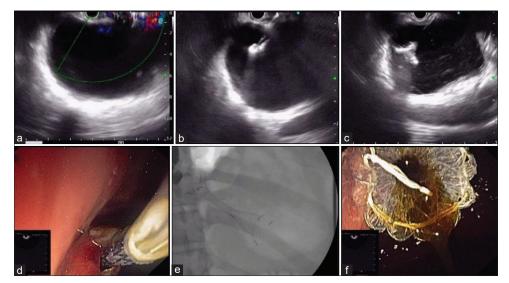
(a) EUS shows a pseudocyst and colour Doppler shows no intervening vessels. (b) Puncture of pseudocyst with 10-French cystotome. (c) Flanges of the stent seen in the pseudocyst cavity. (d) Endoscopic image of the stent being deployed. (e) Fluoroscopic image of the deployed stent. (f) Endoscopic image of the deployed stent
